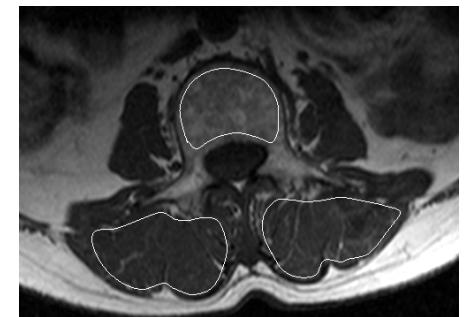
T1-weighted MR image in axial plane, with manually drawn ROI within L3 vertebral body and erector spinae muscle.
